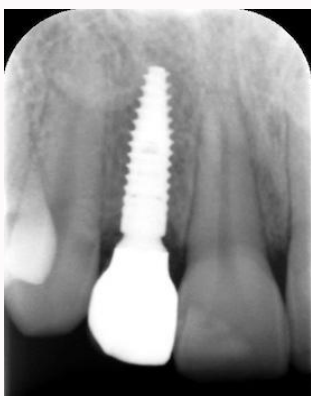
Post –operative radiograph: Radiograph of definitive restoration of maxillary left lateral incisor taken on the day of insertion.
